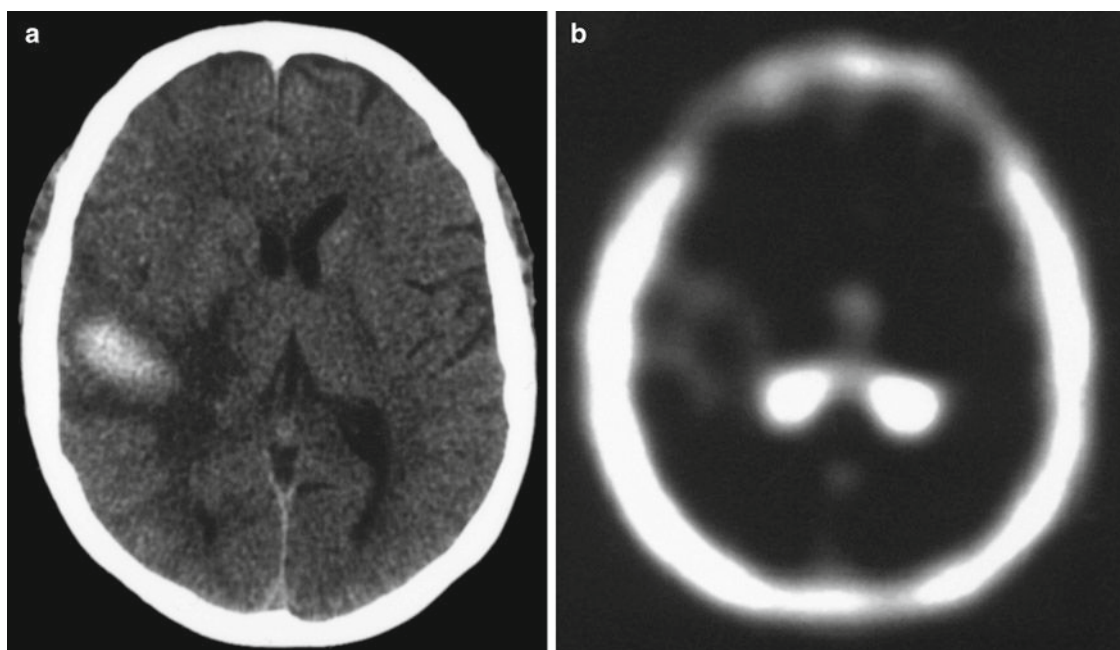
(a) CT scan obtained 9 days after onset of headache not responsive to standard therapy and progressively worsening, shows an atypically located brain hematoma in the right temporal region in a 52 year-old female patient without vascular risk factors. The lesion is surrounded by moderate edema. (b)  $^{99m}\text{Tc}$ -MIBI SPECT, obtained 10 days after symptoms onset, reveals a ring-like MIBI accumulation in the lesional area. One year follow-up suggests the diagnosis of benign brain hematoma
